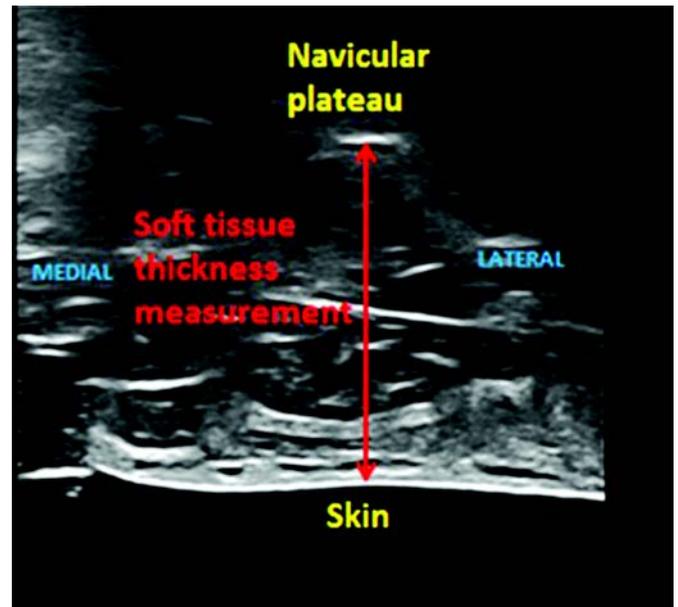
Ultrasound image showing landmarks used to record tissue thickness measurement for baseline arch condition.
